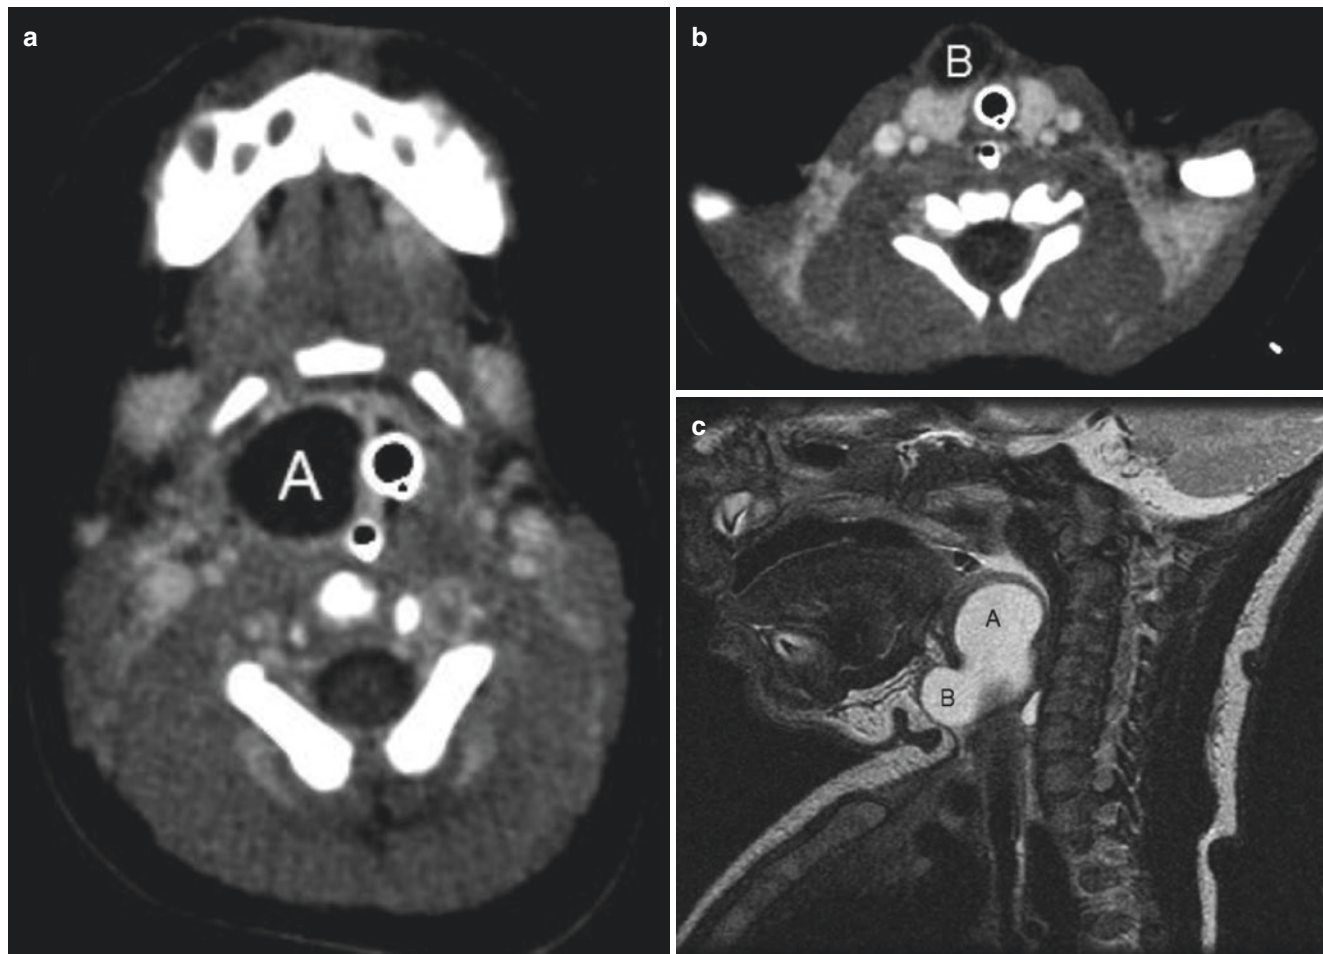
(a) Axial contrast enhanced CT of a newborn with a large obstructive laryngeal cyst taken at the level of the hyoid bone. The intralaryngeal component is labeled (A). (b) Axial CT of same newborn at the level of the thyroid gland showing the extralaryngeal component
